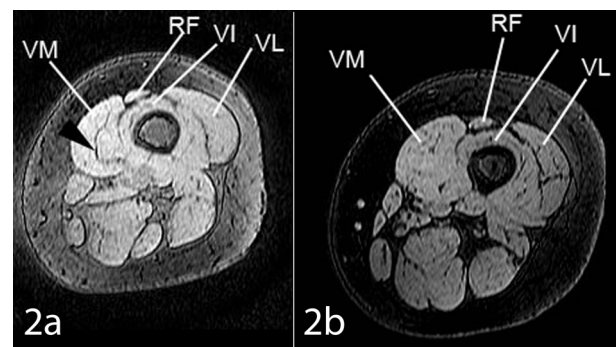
a) Axial MRI, left thigh. RF rectus femoris, VI vastus intermedius, VL vastus lateralis, VM vastus medialis. Black arrowhead indicates plane of separation between VMO (superficial) and VML (deep). b) Control subject. No plane of separation visible in VM at the corresponding axial level. Abbreviations as in Fig. 2a.
